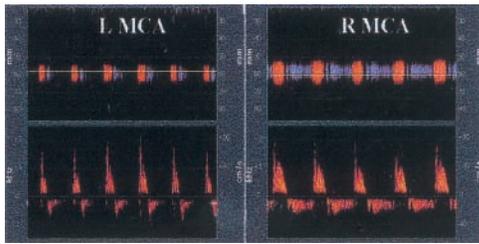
Reverberating flow signature. Both middle cerebral arteries (MCAs) have reverberating flow patterns on both power motion mode Doppler (PMD) and transcranial Doppler (TCD). PMD displays the strongest flow signals (red-to-blue), whereas spectral TCD shows an oscillating flow with a 9-mm gate. The patient had a large right MCA stroke, and 4 days after onset of symptoms had clinical signs of brain death due to supratentorial mass effect and herniation.
